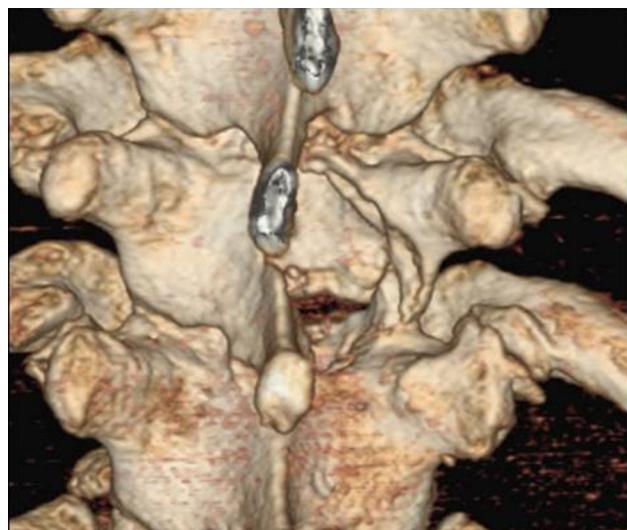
Three-dimensional rendering of postoperative CT scan (Case 1) gives better evidence of the limited amount of bone resection. The bone window is unilateral, the consto-transverse joint is intact
